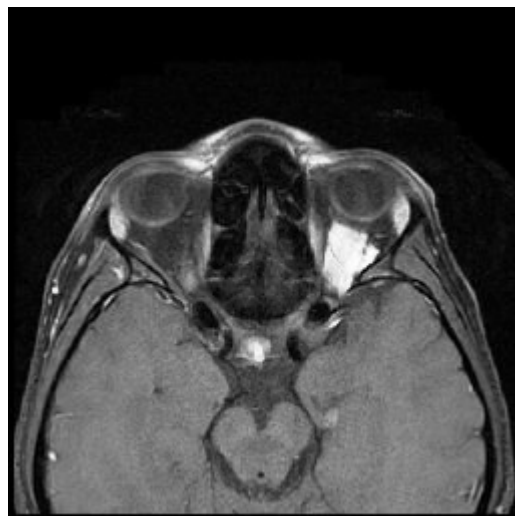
Axial T1-weighted MR image after IV Gad injection in prone position, white arrow indicates intensely enhancing intraconal mass lesion
